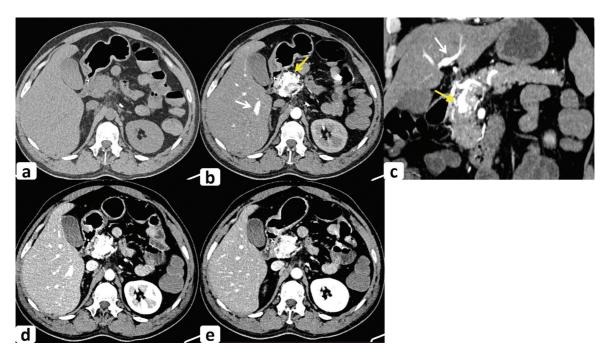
Multiphasic computed tomography (CT) images of a 45-year-old male patient with pancreatic arteriovenous malformation (AVM). (a) Noncontrast axial image showing no obvious abnormality. (b) Arterial phase axial image and (c) arterial phase coronal oblique image, showing multiple arterially enhancing vessels in the region of the head of the pancreas (*yellow arrow*). Early opacification of the portal vein branches can be seen in this image (*white arrow*). Dilated feeder from the gastroduodenal artery can be seen in (c). No abnormality is seen in the rest of the pancreas. (d) Portal venous phase image and (e) hepatic venous phase image showing persistent enhancement of the vascular channels in the peripancreatic region, similar in enhancement to that of the aorta.
